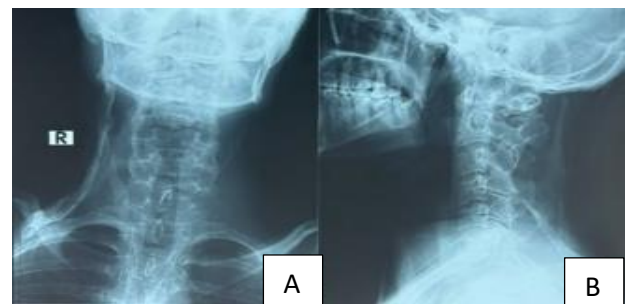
(A and B): X-ray cervical spine (both views) showed extra-skeletal ossification in the sternocleidomastoid muscles, subcutaneous tissue on the right side, and cervical curvature straightening.
